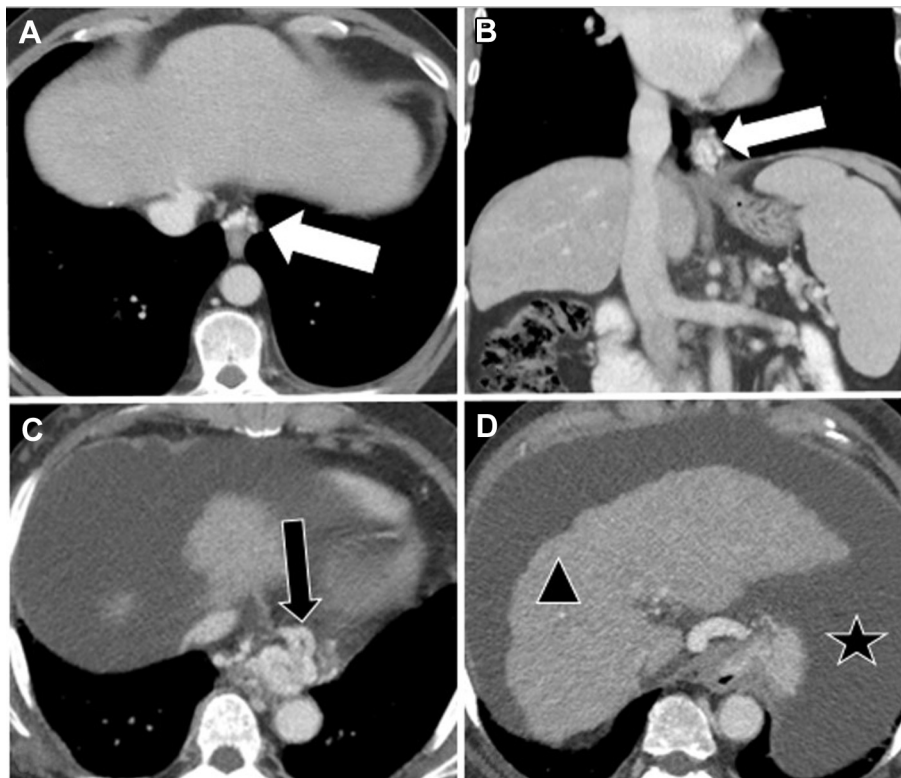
Axial and coronal contrast enhanced CT scan through lower chest demonstrating esophageal varices. A, B, Axial (A) and coronal (B) images of the same patient with esophageal varices. Serpiginous enhancing structures adjacent to distal esophagus, consistent with varices (white arrows). C, D, Axial contrast enhanced CT images through lower chest in different patient with portal hypertension. C, Serpiginous enhancing structures adjacent to distal esophagus, consistent with esophageal varices (black arrow). D, There is a shrunken liver with a nodular contour, consistent with cirrhosis of the liver (triangle). Large ascites is also present (star).
